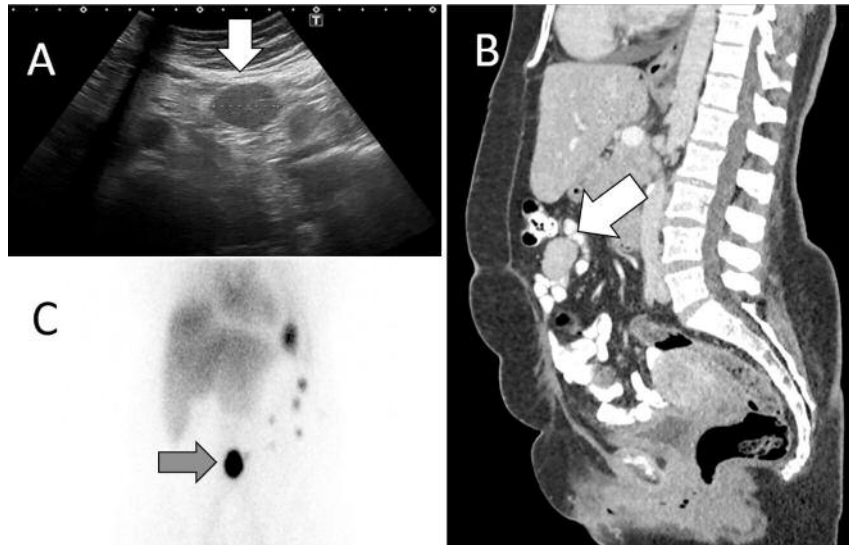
A) Abdominal ultrasound, showing a solid nodule (arrow). B) CT with contrast showing the nodule in the peritoneum, at the level of the navel (arrow). C) Gam-magrapy with denatured red cells marked with technetium-99, confirming the existence of several splenic tissue foci dispersed by the abdominal peritoneum, the largest paraumbilical (arrow).
